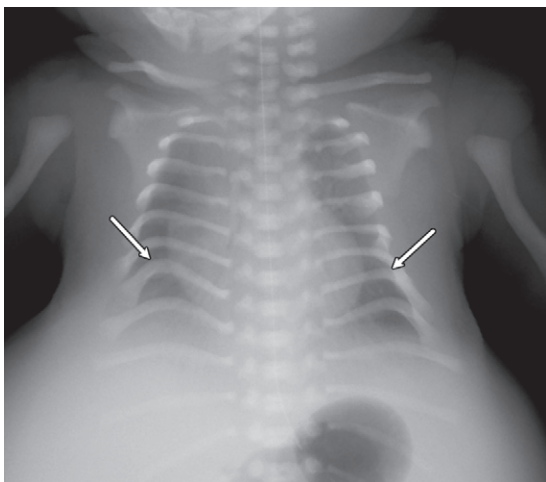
Coat-hanger ribs in a neonate with Sensenbrenner syndrome. Frontal chest radiograph shows coat-hanger–appearing ribs in the midlevel ribs (arrows). The upper and lower ribs are relatively normal, as opposed to diffusely abnormal ribs seen in paternal uniparental disomy 14.
